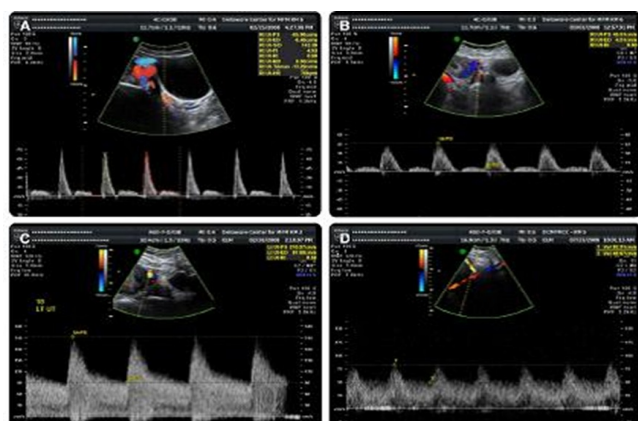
Depiction of Uterine artery Doppler ultrasound in the nonpregnant and pregnant patient
